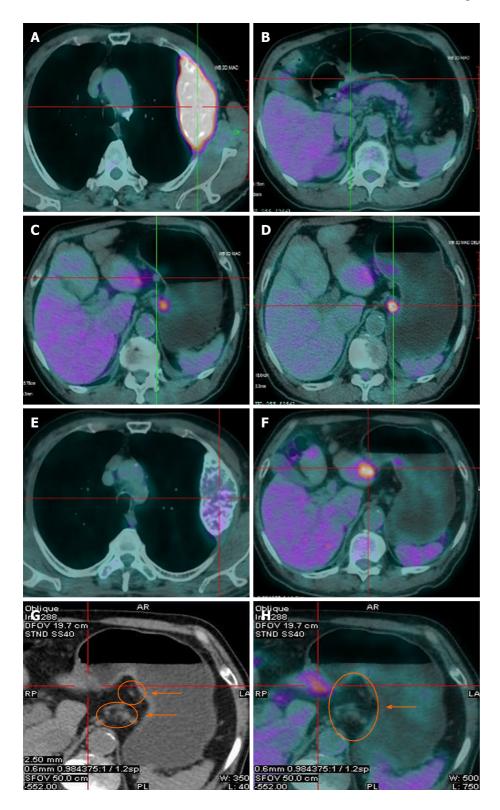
Positron emission tomography/chest computed tomography scanning presentation at different times. A-D: Baseline lesions. A: Rib bone metastasis, SUV_{max} = 8.08; B: Gastric tumor, SUV_{max} = 3.65; C: Metastatic lymph nodes 1, SUV_{max} = 6.5; D: Metastatic lymph nodes 2, SUV_{max} = 3.2. E-H: Changes in the target lesions after five courses of chemotherapy. E: Rib metastasis, SUV_{max} = 2.65; F: Gastric tumor, SUV_{max} = 3.58; G and H: Metastatic lymph nodes, $SUV_{max} = 0$.
